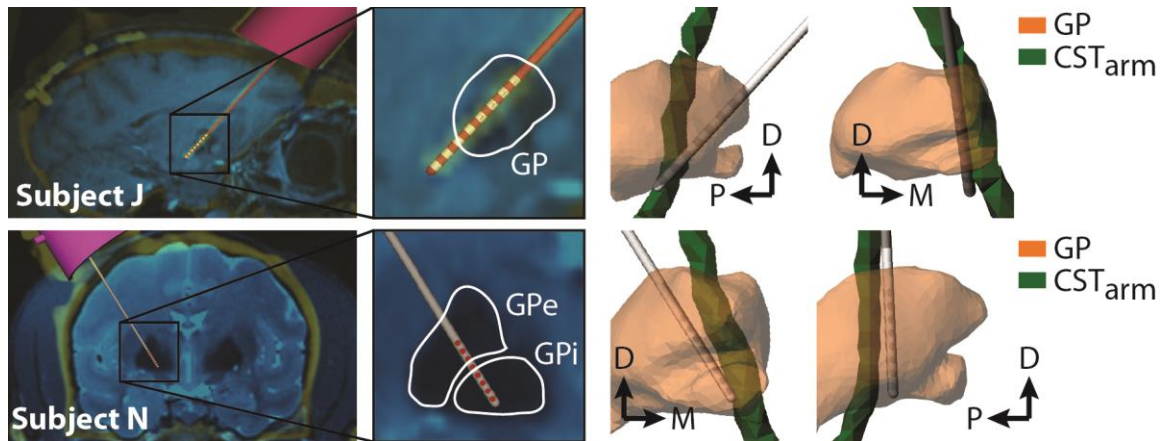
Image co-registration and model lead placement. Preoperative MRI was co-registered with postoperative CT in order to confirm the location of the implanted lead (left). The lead, the globus pallidus (GP), and the arm representation within the corticospinal tract ( $CST_{arm}$ ) were constructed for each subject (right).
